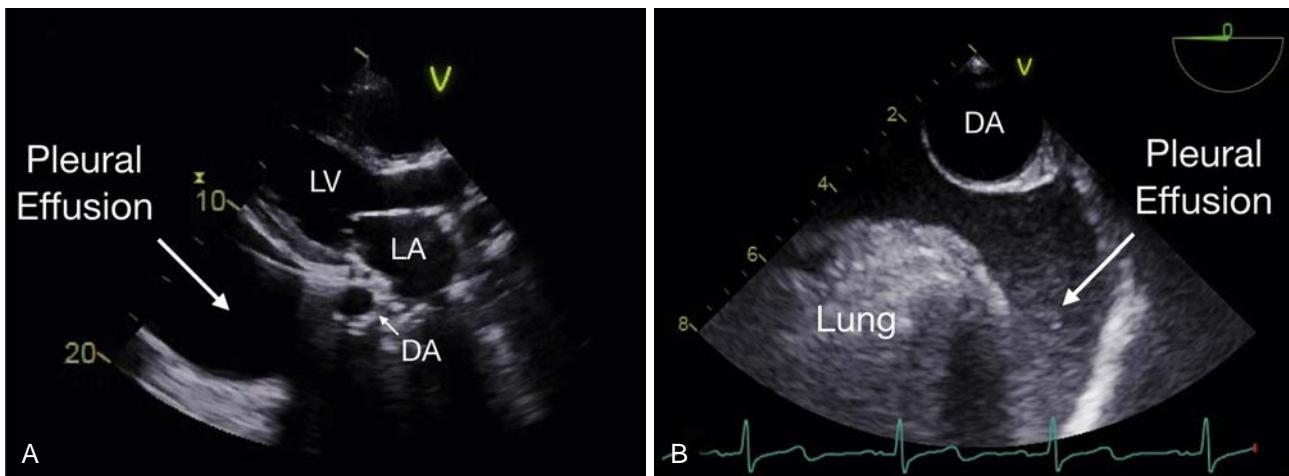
Pleural effusions demonstrated by echocardiography. (A) This transthoracic parasternal long axis view demonstrates an echolucent space posterior to the DA, consistent with a large left pleural effusion. A pericardial effusion (not present in this image) would be seen as an echolucent space anterior to the descending aorta. (B) A transesophageal descending aorta short axis view demonstrating an echolucent space consistent with a left pleural effusion. Note the atelectatic lung at the left of the image. DA, Descending aorta; LA, left atrium; LV, left ventricle.
